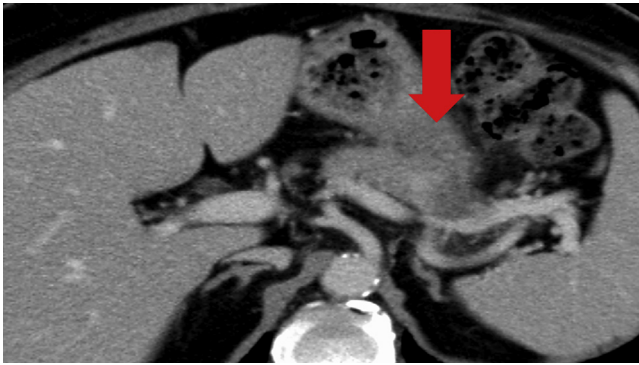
CT view on day 16 showing disappearance of most of the gastric wall abscess.
